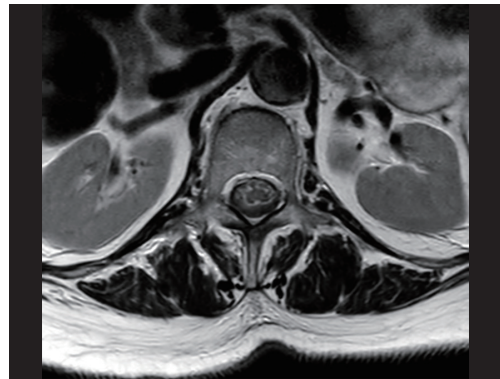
MRI (T2 sequence, axial) showing a spinal subarachnoid hemorrhage that compress the spinal cord at lumbar vertebrae 2 level. MRI, magnetic resonance imaging.
